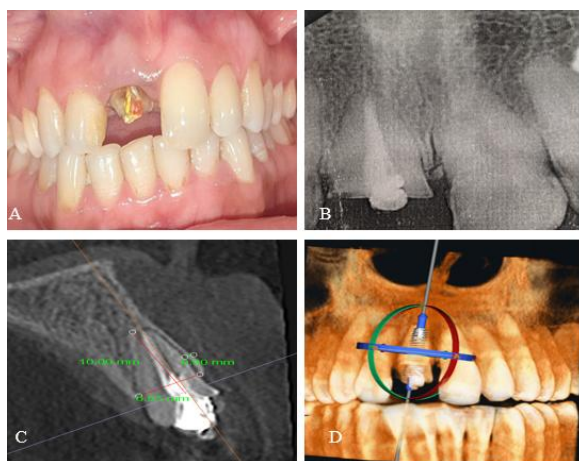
(A) Grossly destructed 11 (B) IOPA showing RCT with 11 (C) CBCT showing bucco-palatal dimensions and root length (D) Virtual implant planning.
